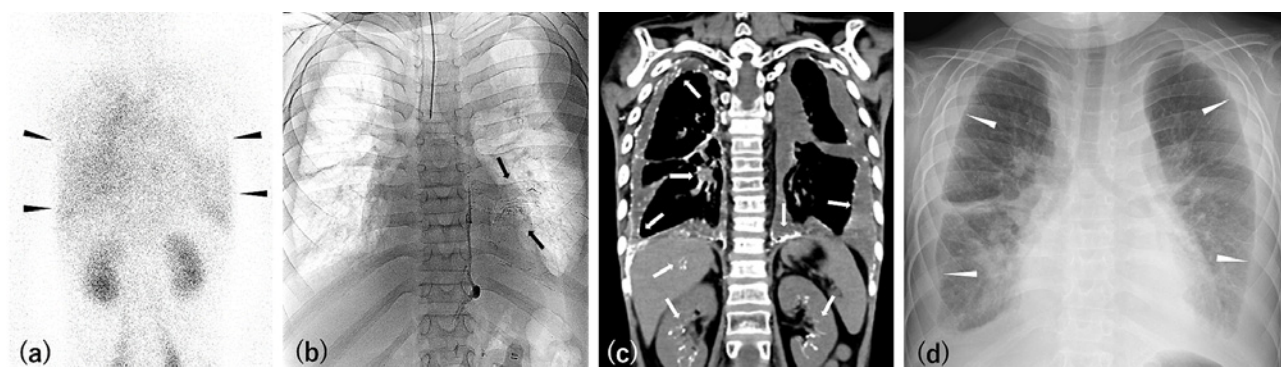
(a) A lymphoscintigraphy at 3 h post subcutaneous injection of technetium-99m diethylenetriaminepentaacetic acid human serum albumin showed abnormal uptake in the chest, implying pulmonary lymphatic backflow (black arrowheads). (b) A fluoroscopic image captured during lymphangiography, showing abnormal ionized oil flow to the left intrapulmonary lymphatics (black arrows). Bilateral pleural effusion is also observed. (c) A computed tomographic (CT) image captured after lymphangiography, showing ionized oil deposition in visceral pleural, peribronchovascular, renal hilar, and intrahepatic lymphatics (white arrows). (d) A chest radiograph taken 4 months after the lymphangiography, showing a decrease in the pleural effusion (white arrowheads).
